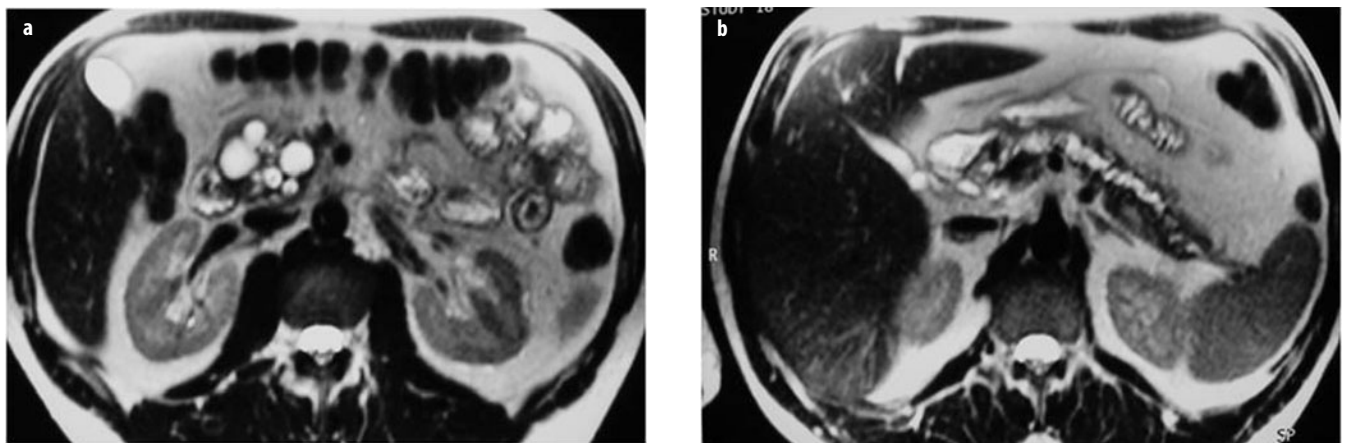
a, b. Cholangiopancreatography (CP). a Cystic degeneration of the pancreatic head, together with b irregular dilatation of the pancreatic main duct on magnetic resonance imaging (MRI) (fast spin-echo, T2-weighted). Note the similar imaging appearance to other cystic lesions of the pancreas
